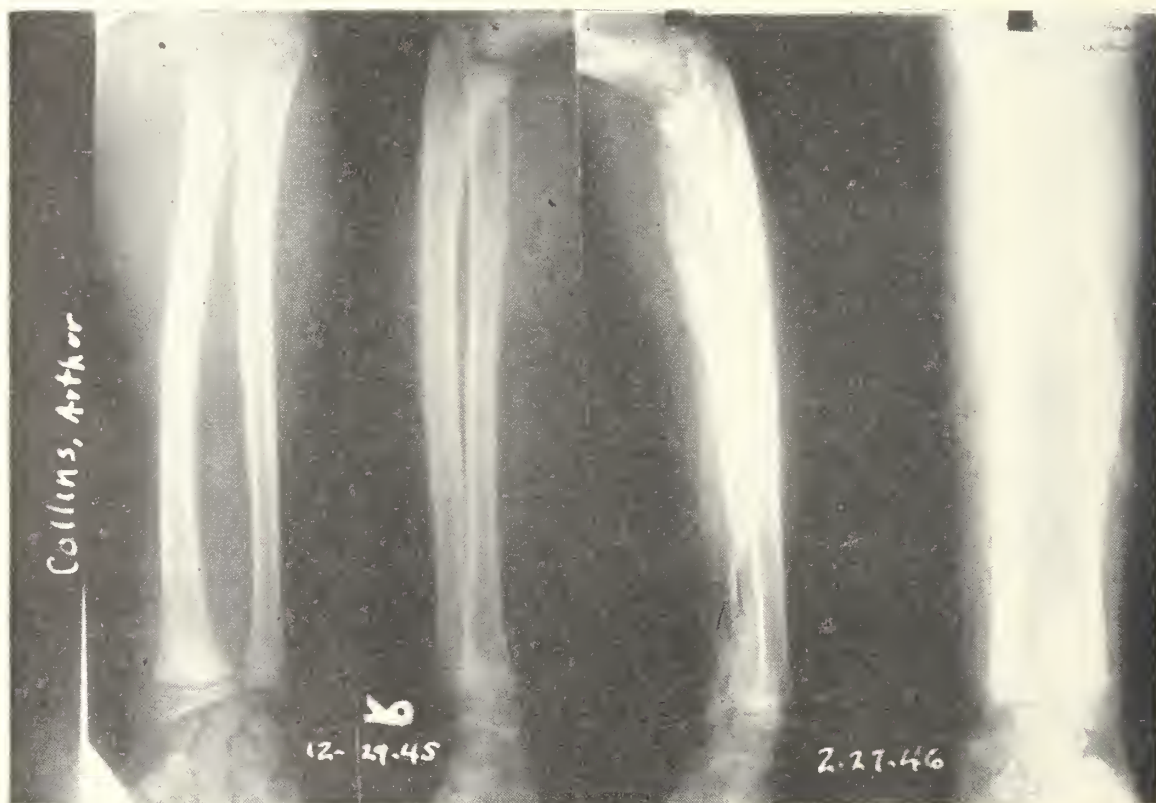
Case 1. Roentgenograms, December 29, 1945, and February 27, 1946. Non-operative treatment of acute hematogenous osteomyelitis: Preliminary report. John J. Killefer, M.D., and Robert C. Robertson, M.D.
